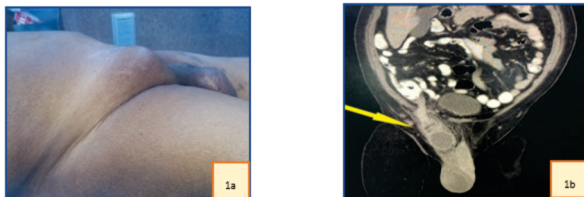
a) Local Examination showing large, tender lump in right groin region. b) Computed Tomography showing Appendix herniating through Inguinal canal with wall thickening and distal fluid distension.
